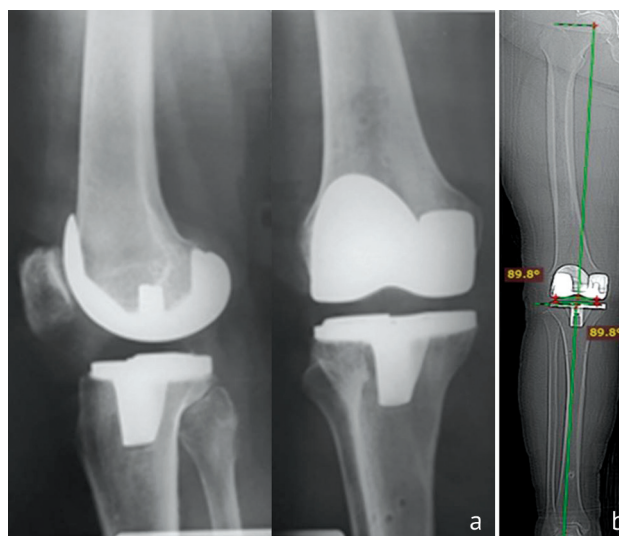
Postoperative knee joint radiographs in AP and lateral views (a) and full-length lower limb radiograph (b)
